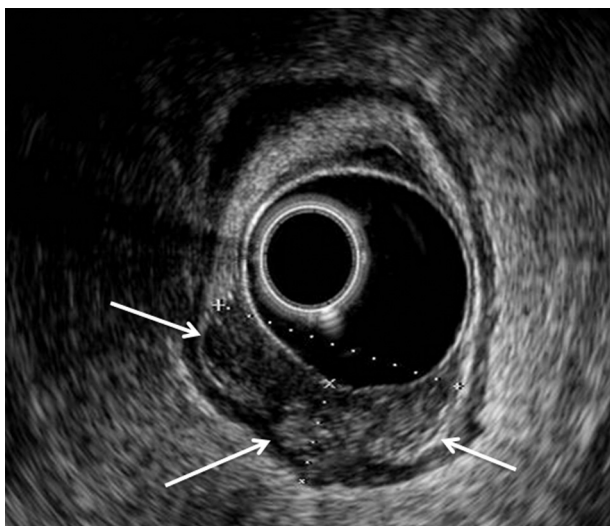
Endorectal ultrasonography (ERUS) image of T3 rectal tumor (arrows). Note the small field of view of the ERUS image.
